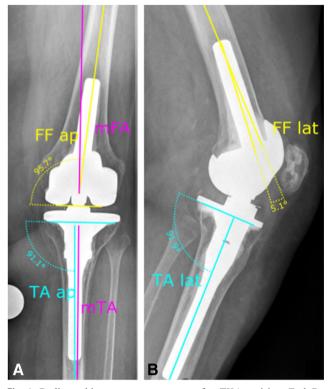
Radiographic outcome parameters after TKA revision: EnduRo prosthesis 1 year post-operatively anterioposterior (ap) (a) and lateral (lat) (b); FF, femoral flexion angle; TA, tibial angle; mFA, mechanical femur axis; mTA, mechanical tibia axis. Mechanical femoro-tibial angle is the angle between mFA and mTA
